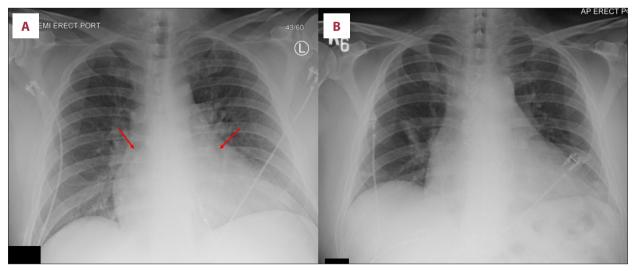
(A) Initial chest X-ray, demonstrating subtle, but well-circumscribed, opacity underlying the cardiac silhouette (red arrows). (B) Postoperative chest X-ray without the density.
